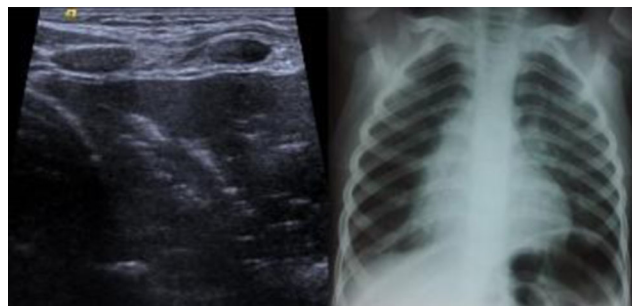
Paracardiac right-sided pneumonic lung consolidation with moderate air-bronchogram showed by lung ultrasound (left image), confirmed later by chest X-ray (right image).
